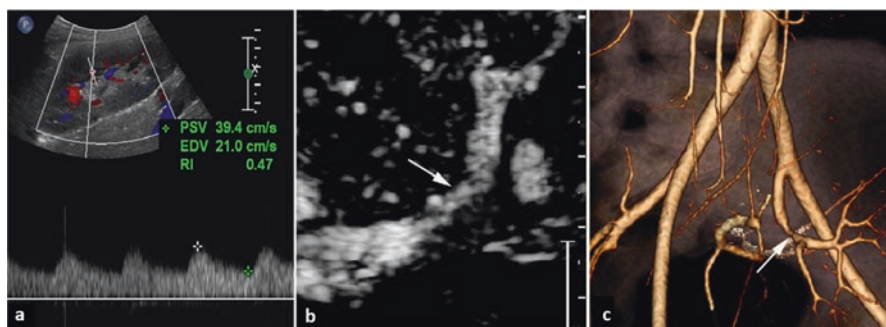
Doppler ultrasound shows potential stenosis of a patient with transplant renal artery stenosis (TRAS) (a). Microbubble-enhanced ultrasound shows the narrowing of the renal artery (b, arrow), which was confirmed by computed tomography angiography (c, arrow). (Adapted with permission from [64])
